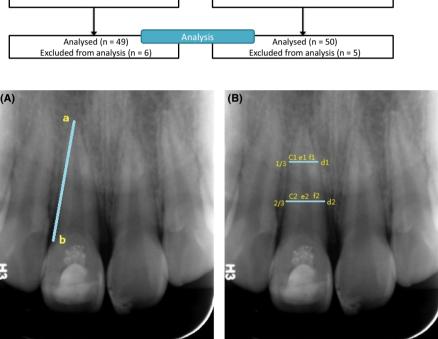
A, The root length is measured along the straight line between a (the midpoint of the radiographic apex) and b (the cementoenamel junction). B, The dentin wall thickness is measured by subtracting ef (the width of the pulp space) from cd (the width of the root)
